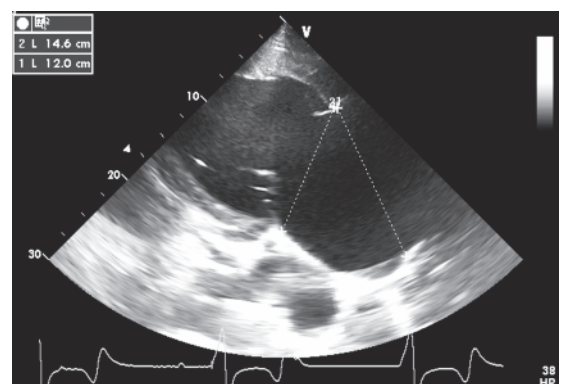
Right parasternal long axis echocardiographic image of the left ventricular outflow tract and aorta. Echocardiographic examination revealed an enlarged right ventricle and right atrium.
